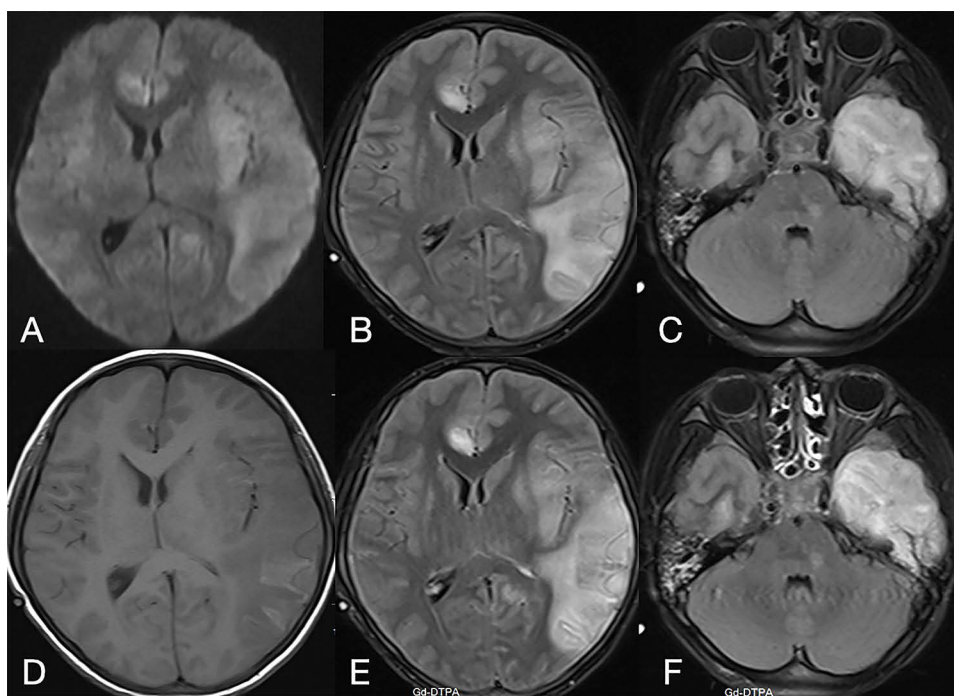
Plain and contrast-enhanced MRI images of the brain of Patient 3.
